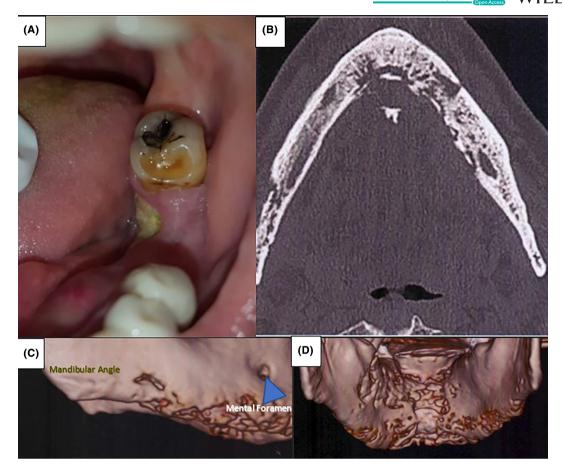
Clinical and radiological features. (A) An area of exposed bone with suppuration on the left side of the mandible, lingual to the 36. (B) Axial CT scan view of the mandible showing ill-defined mandibular mixed sclerotic pattern consistent with osteonecrosis. (C, D) Mandibular buccal cortical destruction and extensive lingual cortical destruction.
